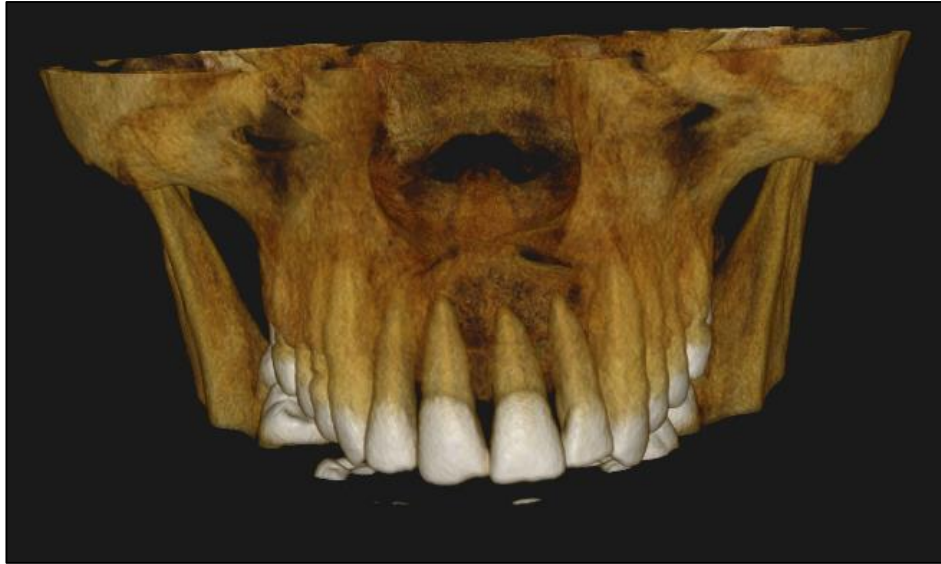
3D reconstruction CBCT showing well defined radiolucency with apices of 11,21 ,22.
